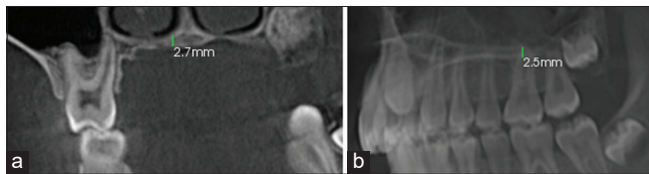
(a) Measurements done on cone-beam computed tomography at the 1<sup>st</sup> premolar site coronal view. (b) Measurements done on cone-beam computed tomography at the 1<sup>st</sup> premolar site sagittal view.
